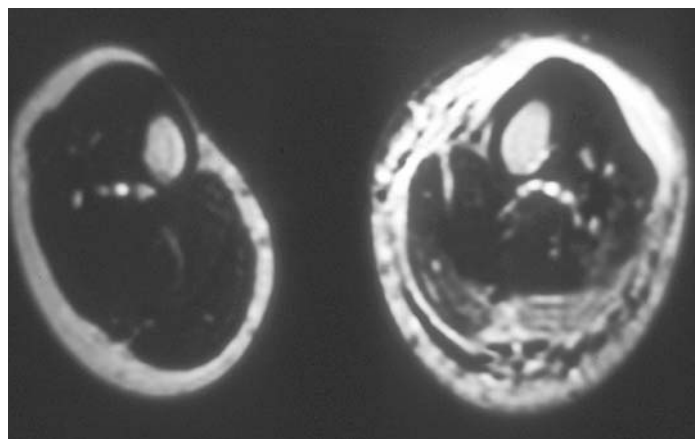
Lower-extremity MRI of a patient with necrotizing fasciitis of the left leg demonstrates inflammatory changes typical of necrosis.
